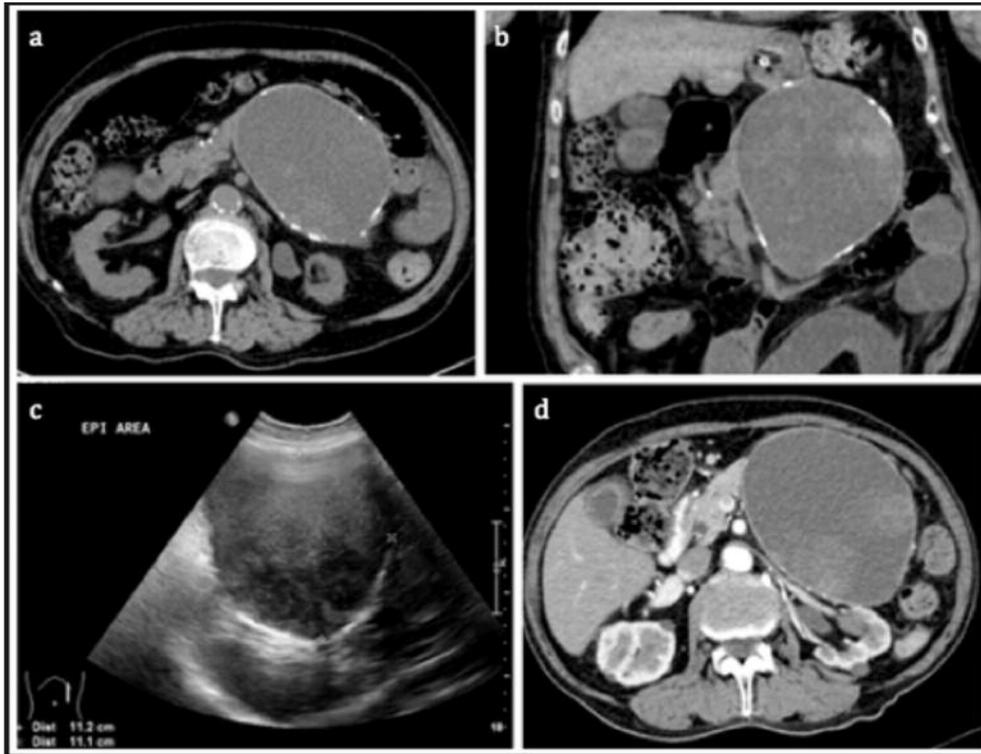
(a, b): Axial and coronal unenhanced CT was performed for this patient with renal impairment and vague symptoms of abdominal discomfort. This reveals a partially rim-calcified complex cystic lesion in the pancreatic body and tail. Abdominal ultrasound (c) performed also demonstrates a complex solid-cystic lesion that corresponds to the above lesion. This patient presented previously with clinical symptoms of pancreatitis, and a review of CECT (d) performed 5 years ago showed that the lesion was unchanged in size and configuration, and subsequent EUS (not included) confirmed that this was a pancreatic pseudocyst. No complications from the pancreatic pseudocyst were detected.
